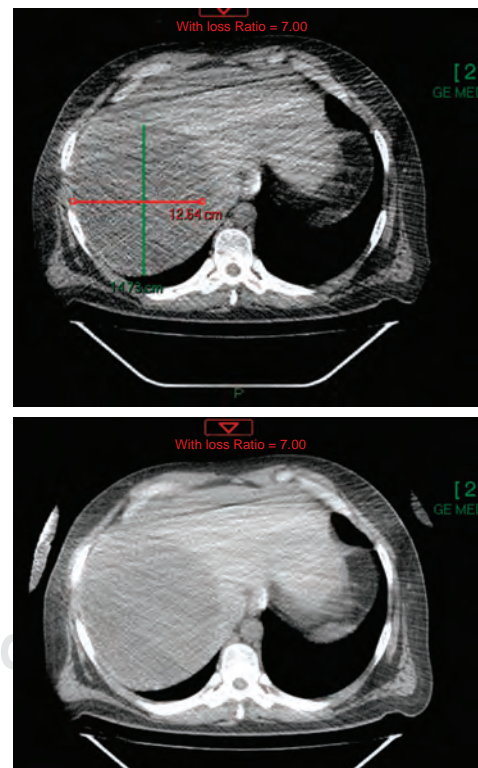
Thorax and abdomen simple computed tomography scan. Axial section showing a liver cyst in the right lobe measuring 12.64 × 14.73 cm.*
